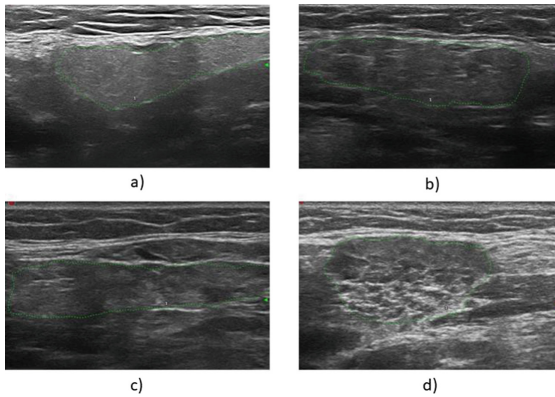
Ultrasound images of pSS: (a) Grade 0, (b) Grade 1, (c) Grade 2, (d) Grade 3
